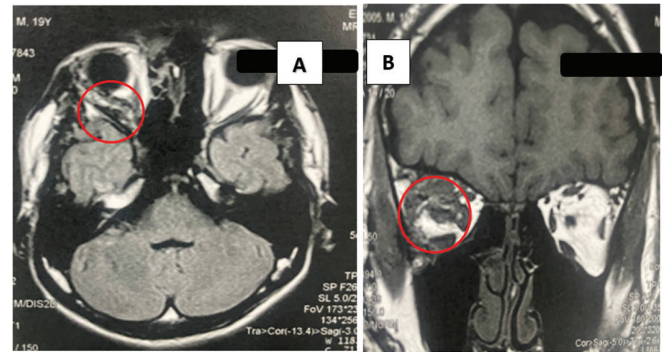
A & B show an MRI of the orbit with Coronal and Axial views demonstrating an irregularly shaped retrobulbar abnormality that projects toward the region of the right apex
